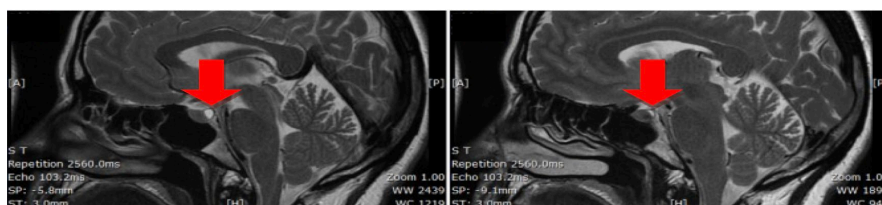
Magnetic resonance imaging at the time of diagnosis.
